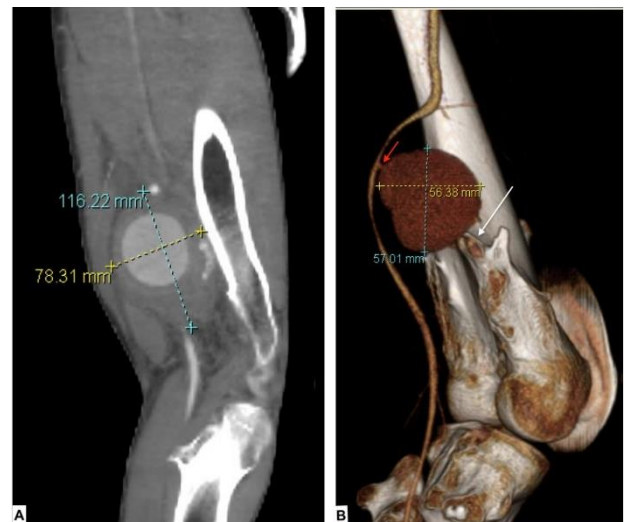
A) CTA MIP and B) 3D reconstructions. A) Measurements of the entire pseudoaneurysm (11.6 x 7.8 cm) with a central contrast filled portion representing active extravasation and a non-filling peripheral portion representing a hematoma. B) CTA 3D marks the measurement of the active part of the pseudoaneurysm on the anterior surface of the left SFA. It has a narrow neck (red arrow) and it is adjacent to a sharp-tipped (white arrow) osteochondroma arising from the medial supracondylar line.
